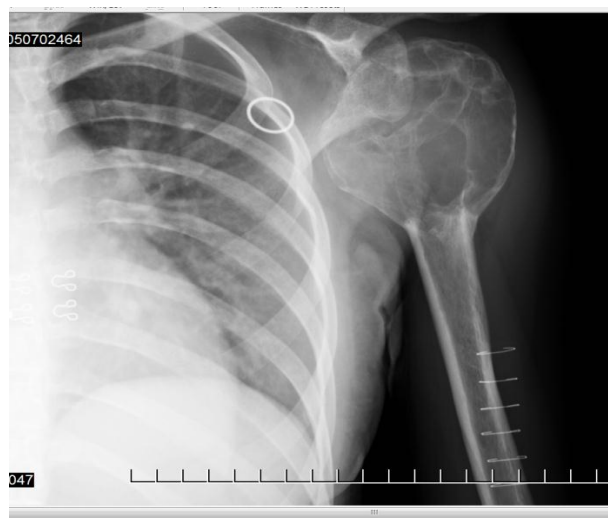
№ 4: Radiography: Patient: A. 22 years old.
